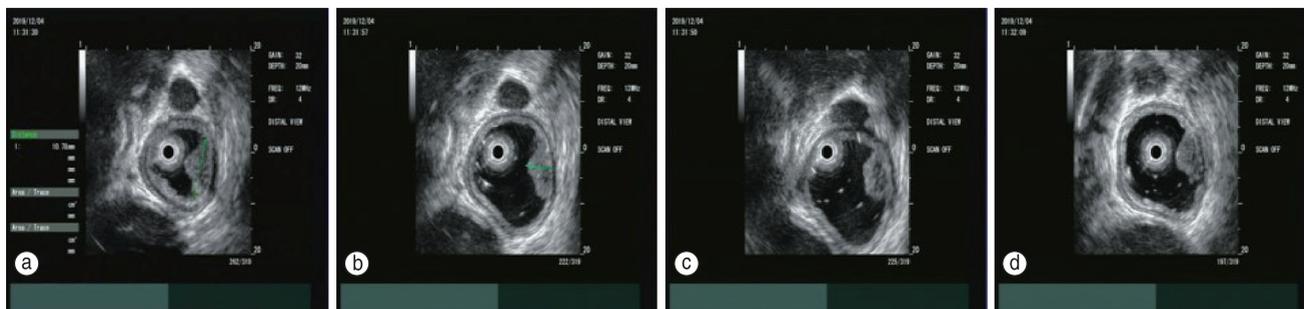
Ultrasound endoscopic ring scan: At the esophageal bulge, see a lesion of about 1 cm in diameter, located in the mucosal layer, and the echo is heterogeneous
